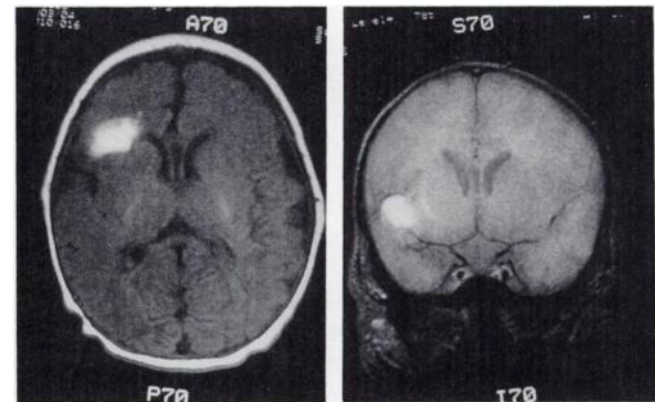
MRI of Patient 9. Transaxial and coronal slices demonstrate hemorrhagic infarct in the right fronto-temporal region. US was abnormal as well.
